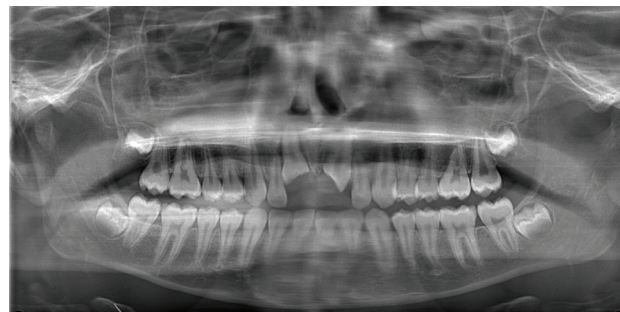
Panoramic radiographs of the patient at initial presentation
